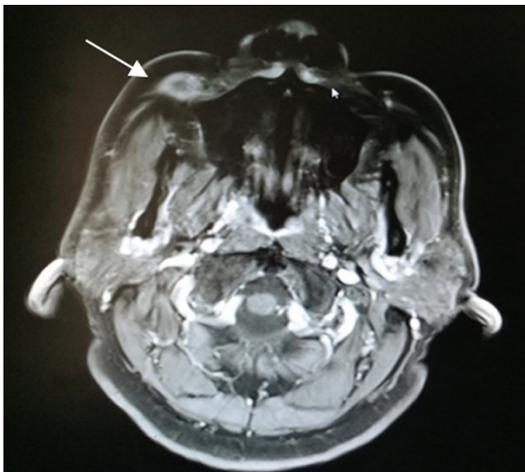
MRI image of the soft-tissue metastasis of rectal adenocarcinoma.
